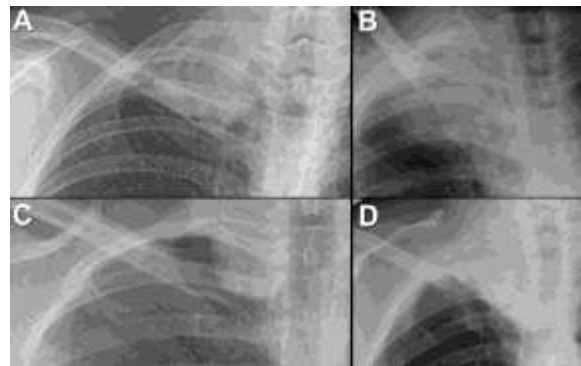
Focused frontal chest radiographs showing (A) The current patient (see Figure 1A); (B) a right subclavian artery pseudoaneurysm in an intravenous drug user;
